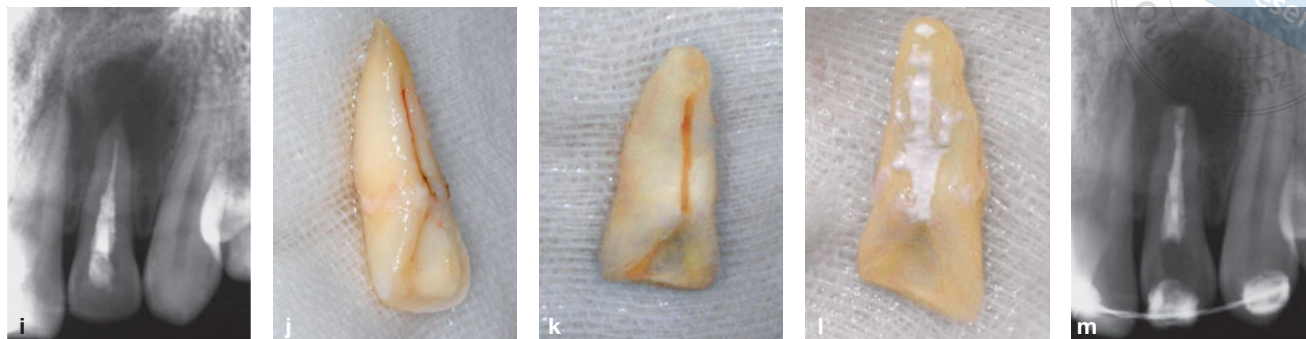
(cont.) (i) Radiograph taken after RCT. (j) The extracted tooth was placed in a sterile gauze soaked with saline solution. (k) The palatogingival groove was removed with a diamond bur, and the apical 3 mm of the root apex was resected and retrogradely prepared. (l) Both the palatogingival groove and the root apex were filled with MTA. (m) Radiograph taken after intentional replantation.
